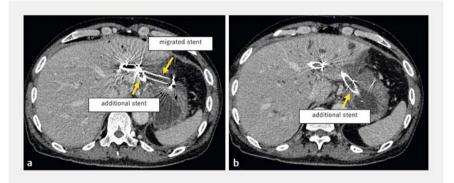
Computed tomography of additional stenting by the partial stent-in-stent method. The migrated stent is seen in the abdominal cavity and the additional stent in the stomach.
